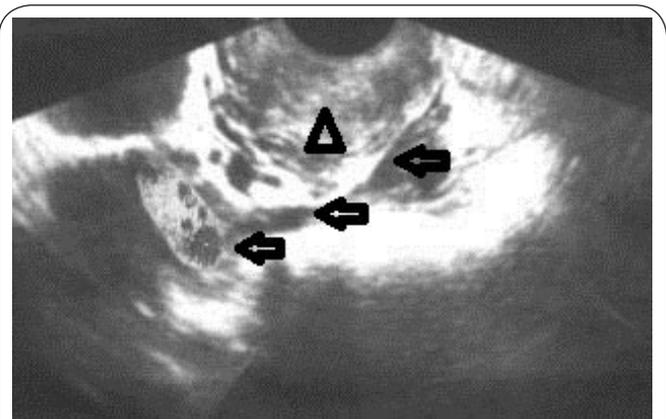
Vaginal hystero-salpingography contrast sonography showing the uterus (arrow head), the tube (arrows), the ovary containg growing follicle surrounded by the tubal fimbriae indicating successful picking of ova by the tube.
